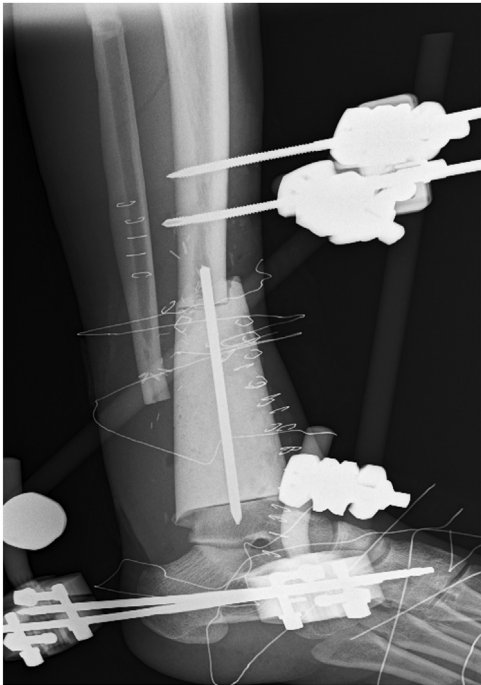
Lateral x-rays of the distal tibia and the ankle following implantation of the second spacer.
